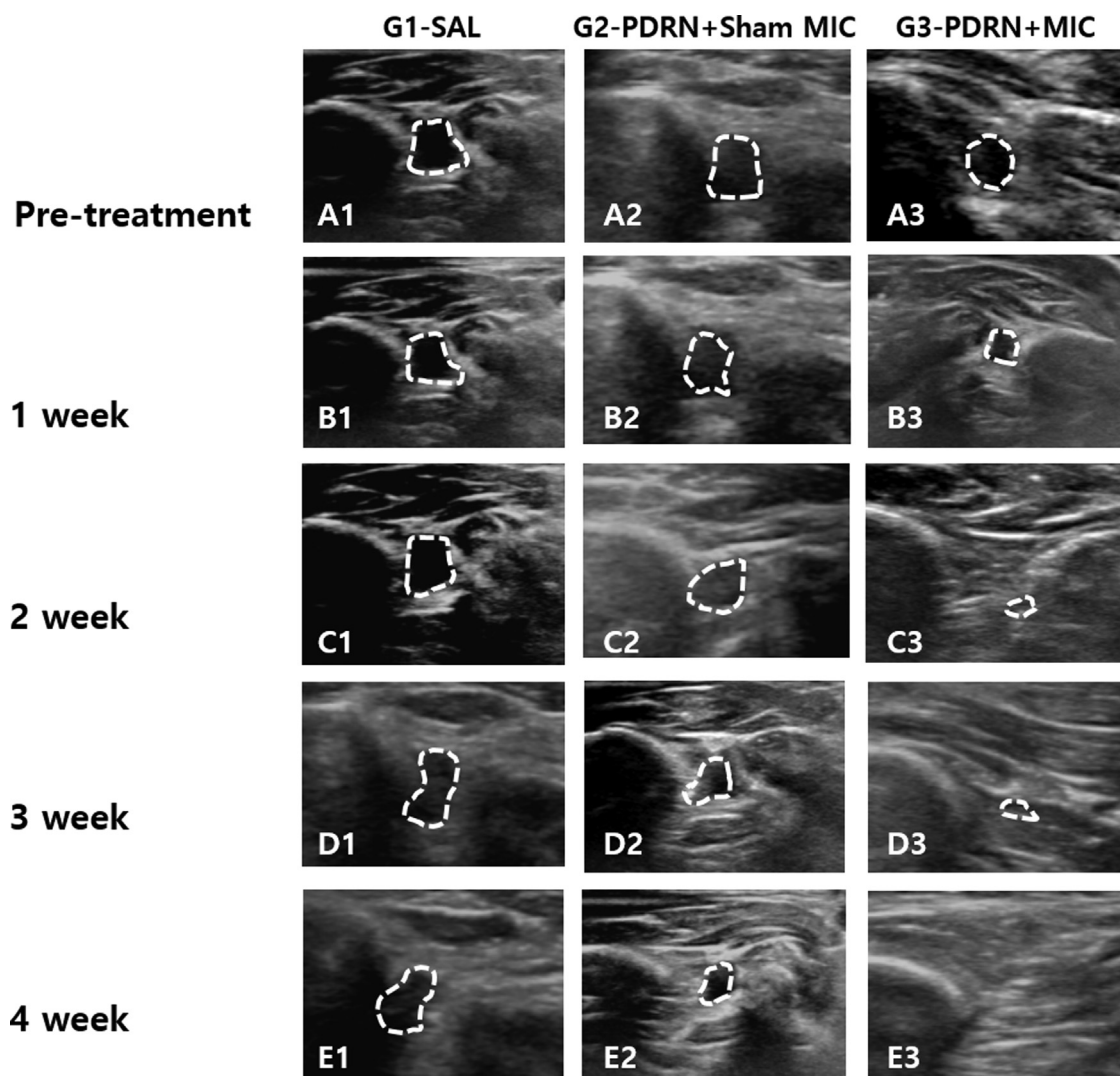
Sequential changes in ultrasonography findings of subscapularis tendon tear at pre-treatment and 1, 2, 3 and 4 weeks post-treatment. Ultrasonography (A1–E3) findings of the subscapularis tendons in G1-SAL, G2-PDRN + Sham MIC, and G3-PDRN + MIC groups.
